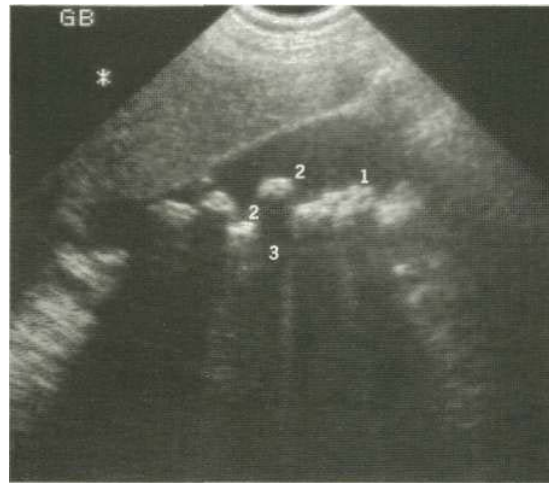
Gall bladder ultrasound with multiple echogenic gallstones causing well-defined acoustic shadowing. 1, gall bladder; 2, gallstones; 3, echogenic shadow.
